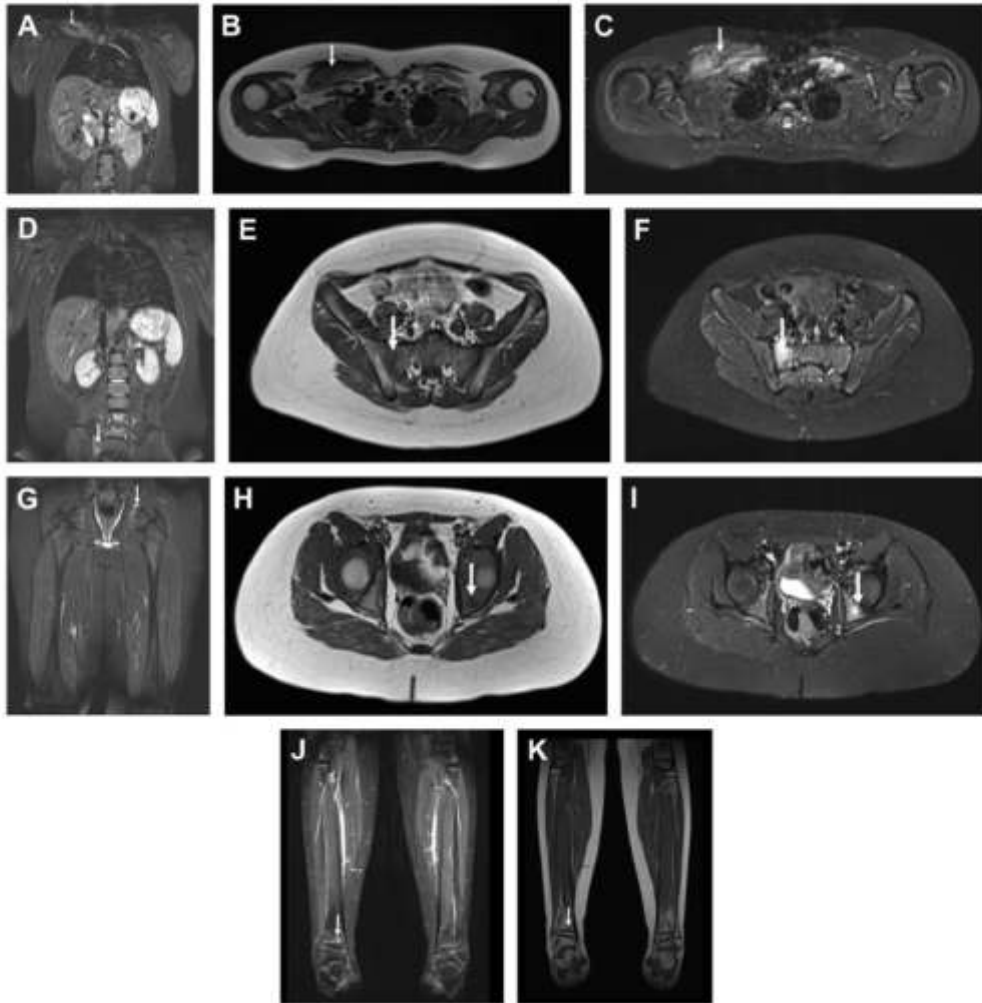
WB MRI of an 11-year-old boy with SAPHO syndrome demonstrating the edema and periosteal reaction of the right clavicle (coronal short tau inversion recovery-STIR in A, axial T1weighted turbo spin echo-TSE in B and axial STIR in C), bone marrow edema in the right sacrum (coronal STIR in D, axial T1w TSE in E, and axial STIR in F), in the left acetabulum (coronal STIR in G, axial T1w TSE in H, and axial STIR in I), and in the distal metaphyseal area of the right tibia (coronal STIR in J and coronal T1w TSE in K).
